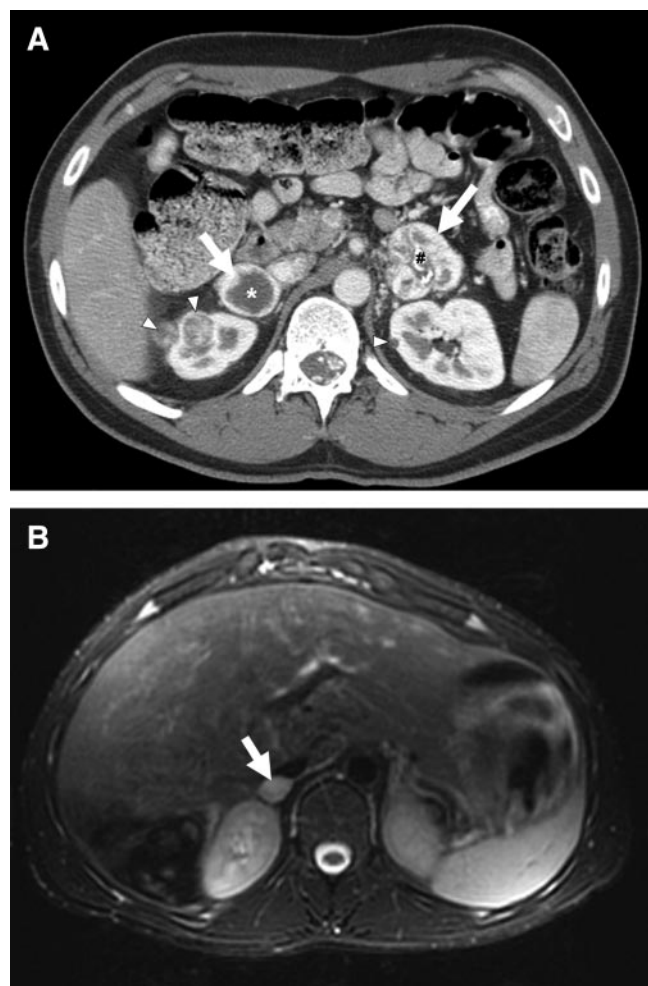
PHEO. A, Bilateral PHEO (white arrows) in a patient with VHL disease. PHEO are vascular tumors with areas of central necrosis (*) and calcification (#). Note also the solid and cystic renal masses (arrowheads) bilaterally, consistent with renal cell carcinoma and benign renal cysts, respectively. B, T2-weighted axial MRI in a patient with an adrenergic right PHEO (arrow) in the context of MEN2b. Note the classic T2 hyperintensity.
